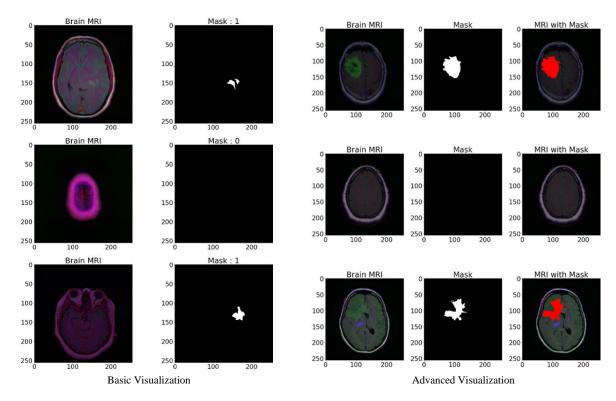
Visualization of TGCA MRI Scan.
